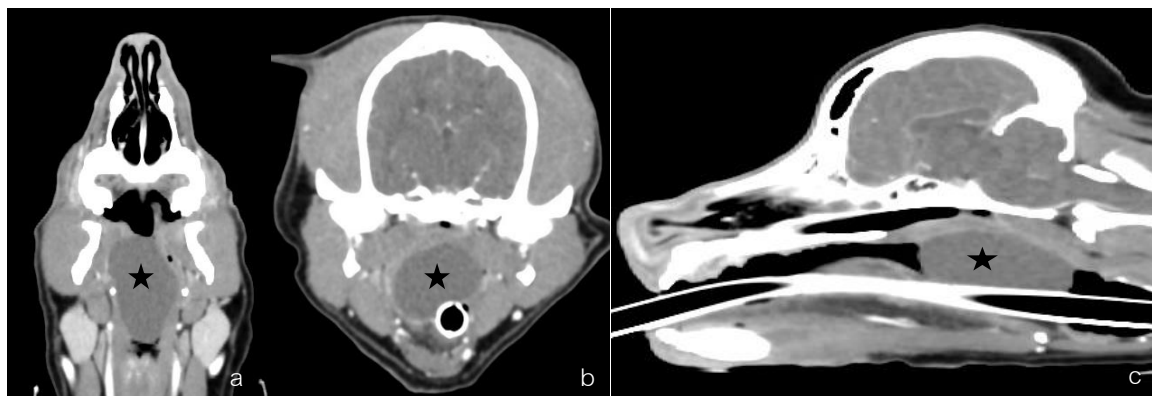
The coronal (a), axial (b) and sagittal plane (c) of computer tomographs (CT) presented a soft tissue mass (asterisk) at the oropharyngeal area. The pharyngeal mass revealed as an encapsulated hypoattenuation mass.
